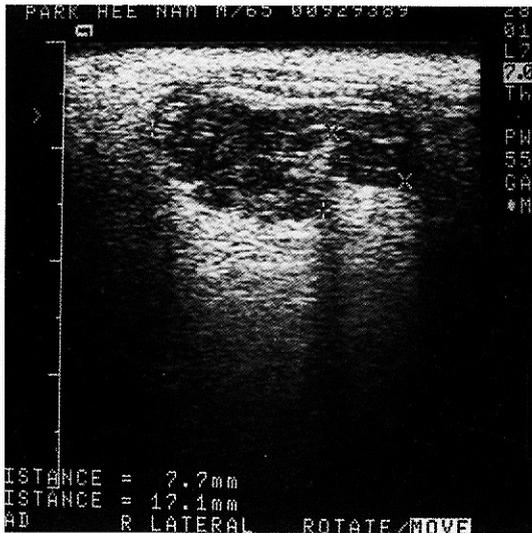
Neck ultrasonography demonstrates a hypoechoic, multilobulated mass lesion within the superficial lobe of the right parotid gland.
